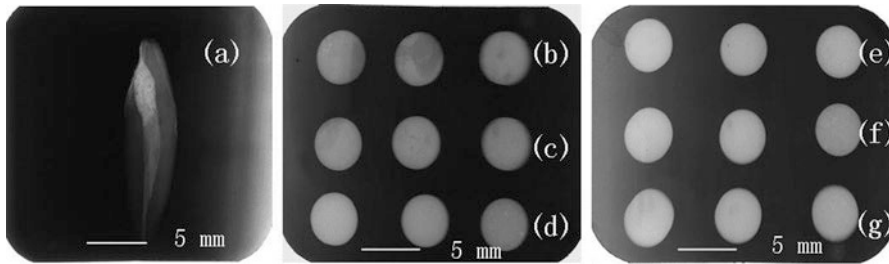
Radiographic images of extracted human tooth, pure ICPC, and BD-ICPCs with different contents of bismuth salicylate basic: (a) extracted human tooth filling with pure ICPC, (b) pure ICPC, (c) BD-ICPC (5%), (d) BD-ICPC (10%), (e) BD-ICPC (15%), (f) BD-ICPC (20%), (g) BD-ICPC (25%) (Reproduced from Ref. [49] by permission. Copyright © 2010 Elsevier Ltd)
